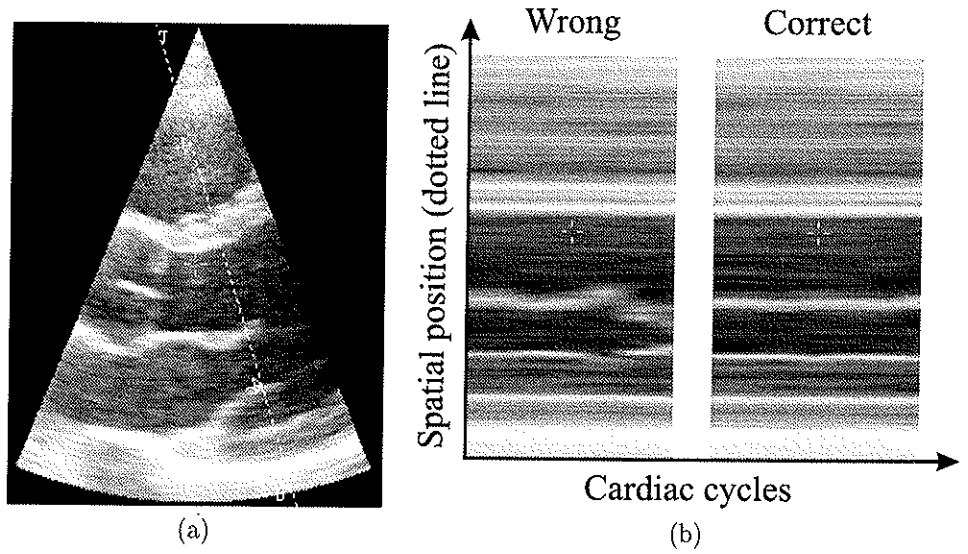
Reconstruction effect of different start frames. (a) The original parasternal long axis scan plane. The dotted line indicates the position of the slices. These slices pass through the mitral valve in the left ventricle. (b) Slice through the mitral valve when reconstruction start frame is at the R-wave (left), and with the start frame 100 ms earlier (right).
